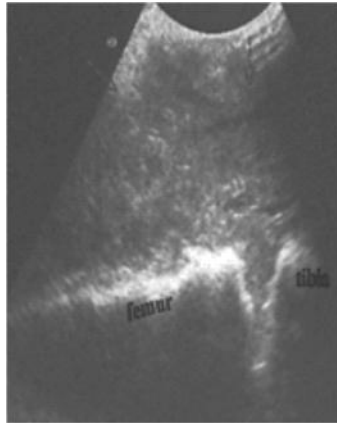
An ultrasonogram of his left knee (38).
